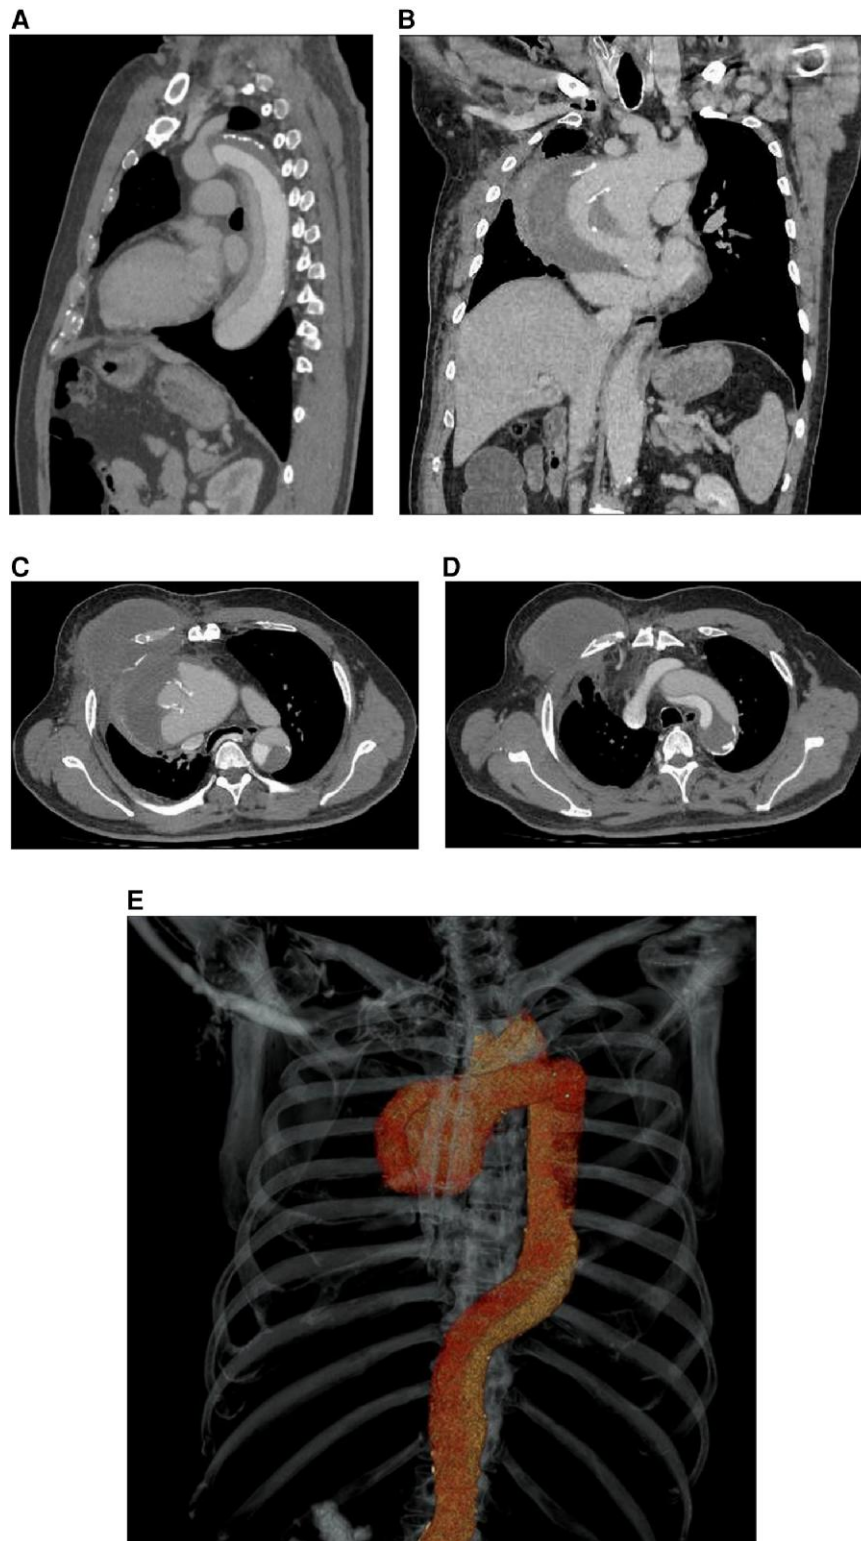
(A) Sagittal computed tomography chest demonstrating aortic aneurysm in the descending aorta. (B) Coronal computed tomography chest demonstrating ascending aorta trajectory, aneurysm starting in the sinotubular junction and extending to the aortic arch, with an intraluminal aortic ring (used in Castro Bernardes procedure); voluminous aneurysm with thrombus and contrast endoleak. (C) Axial computed tomography chest showing Stanford A aortic dissection beginning in the brachiocephalic trunk; costal arches destruction due to pressure mechanisms of aortic dissection. (D) Axial computed tomography chest: aortic aneurysm sac communicating with the right anterior chest wall, creating an aorto-cutaneous fistula. (E) 3D reconstruction.
